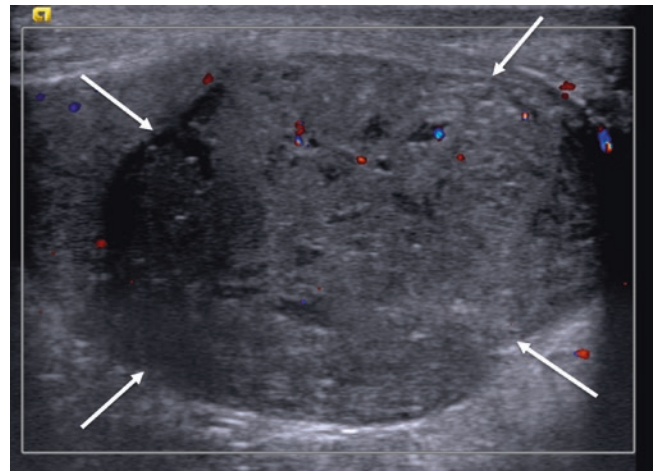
A 24-year-old with back pain. (a) CT of the abdomen and pelvis shows left para-aortic and pre-aortic lymphadenopathy (arrow), suspicious for metastatic left-sided testicular cancer. (b) Gray-scale US of the scrotum shows a left-sided intratesticular, well-circumscribed, lobulated, heterogeneously hypoechoic mass (arrows) with (c) internal flow on Doppler US. These features are the hallmarks of a malignant testicular neoplasm; the final diagnosis of mature teratoma was established after orchiectomy
